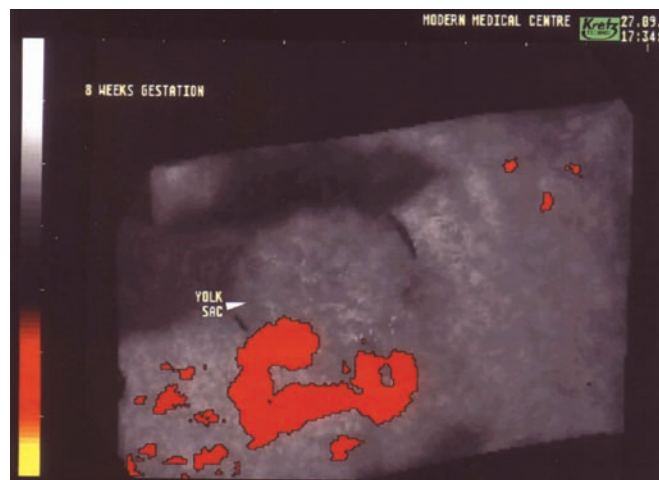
Three-dimensional power Doppler demonstrates turbulent blood vessels above the surface of the yolk sac.
